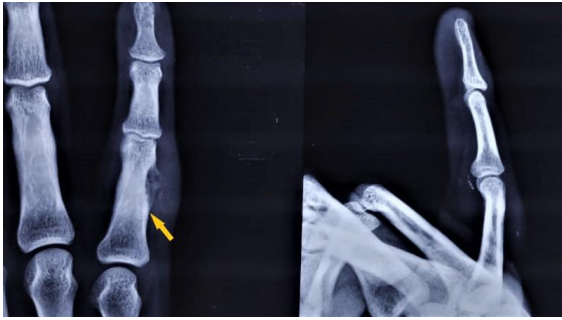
AP and Lateral radiograph of the right little finger shows a lytic lesion with soft tissue component involving the medial aspect of the meta-diaphysis of the proximal phalanx. There is cortical buttressing saucerization seen with associated ring and arc calcification within the soft tissue.
